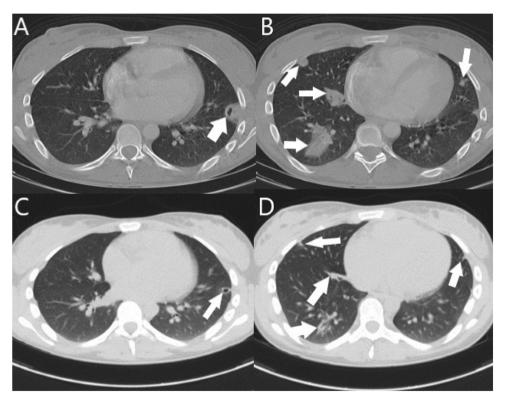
Axial chest CT images: improved radiological findings with involution of pulmonary condensations on admission (A and B) compared to after antibiotic therapy (C and D).
